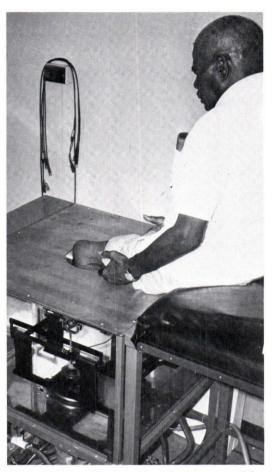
A patient's residual limb is scanned by the ultrasound shape sensing device.
